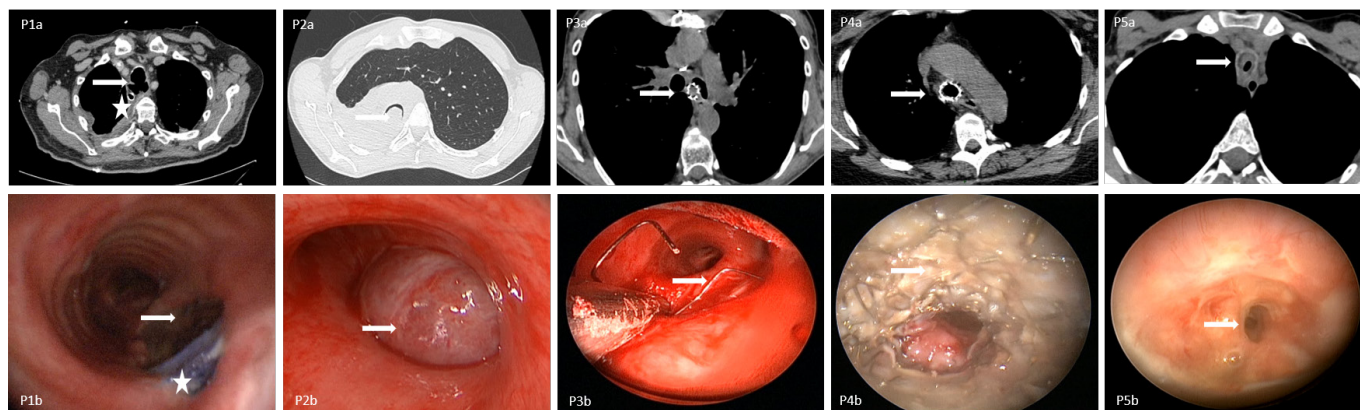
Transversal view of chest CT scan (a) and a bronchoscopic image (b) for each patient. Patient 1 (P1) had a peroperative laceration of the entire trachea (arrow) during total esophagectomy. The chest tube (star) was visible through the tracheal lumen. There was a potential inability to ventilate the lungs using conventional techniques with a major risk of respiratory failure at bronchoscopic Y stenting. Patient 2 (P2) had a huge typical carcinoid tumour (arrow) with a right main stem bronchus obstruction leading to lung atelectasis. A major bleeding was observed at biopsies under flexible bronchoscopy. A risk of massive bleeding with respiratory failure was identified for tumour removal using RB. Patient 3 (P3) had a mediastinal stent migration (arrow) at long-term follow-up after carinal resection and stenting. A risk of massive bleeding with respiratory failure was established for stent removal under RB. Patient 4 (P4) had multiple endoscopic stenting for a severe excessive dynamic airway collapse. Major stent complications (arrow) occurred due to stenosis, obstructive granulation tissue, migration, fracture and infection. There were major risks associated with stent removal, these including mucosal tears, severe bleeding, re-obstruction and respiratory failure. Patient 5 (P5) had multiple tracheal and bronchial stenoses with a residual trachea measuring 3–4 mm (arrow). A potential risk of respiratory failure using conventional or jet ventilation was found. RB, rigid bronchoscopy.
